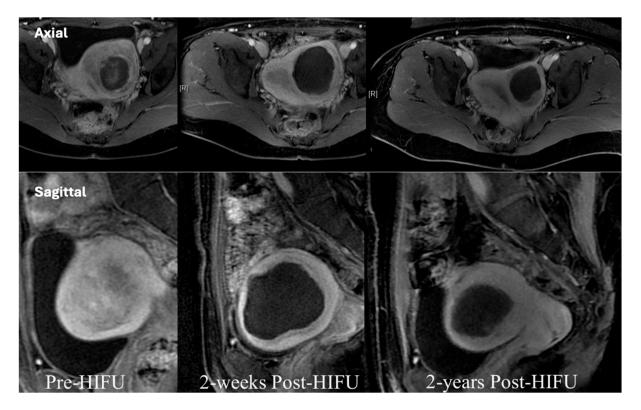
The treatment of uterine fibroids with HIFU (MRI).
